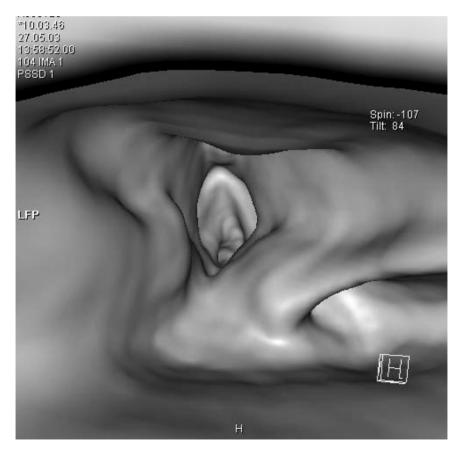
Virtual endoscopic view of the larynx entrance based on S-CT.
